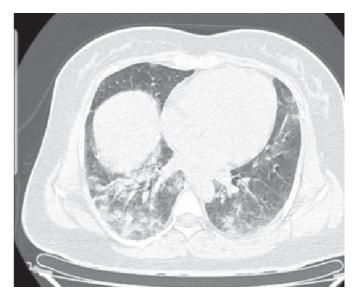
CT chest showing alveolar opacities with airbronchogram involving B/L Lower lobes
